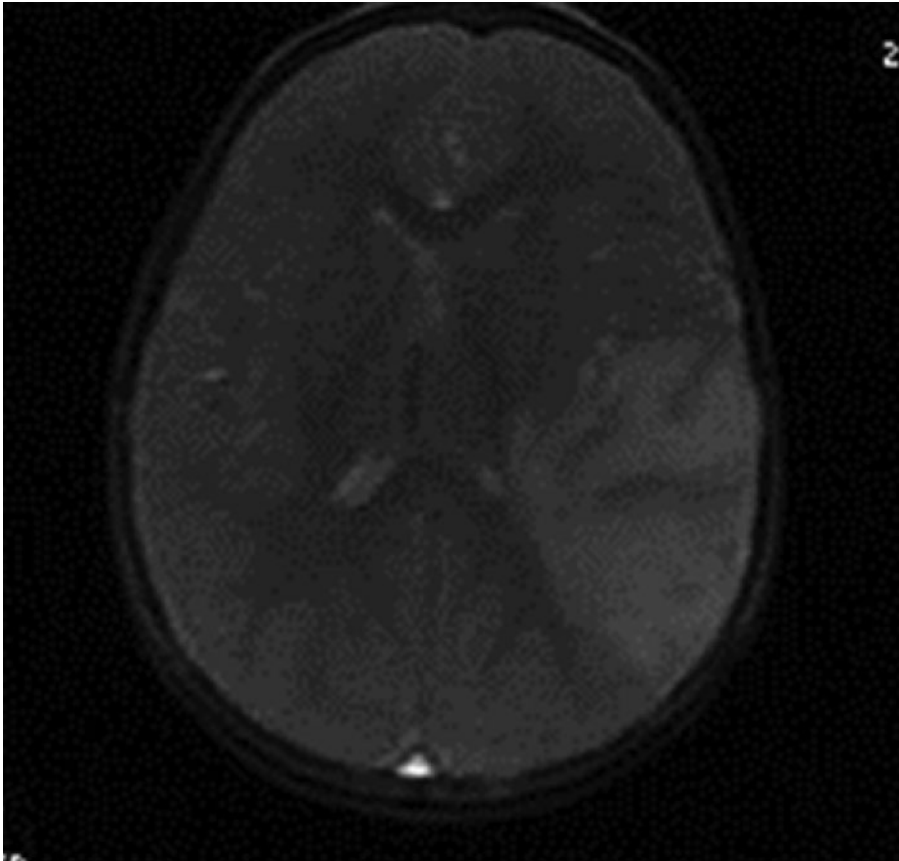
CT scan showing a large left parietal lobe abscess.
